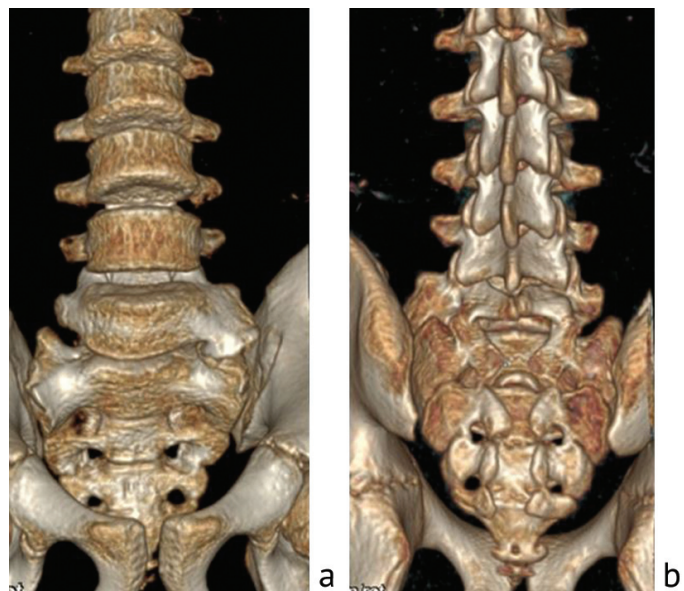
CT scans of the lumbar spine and sacrum of patient M., 13 years old. Transitional (lumbarized) lumbosacral vertebra, type IIa, front view (a). Non-fusion of the posterior part of the arch of the transitional vertebra, non-fusion of the sacral canal (b); authors' clinical observations
